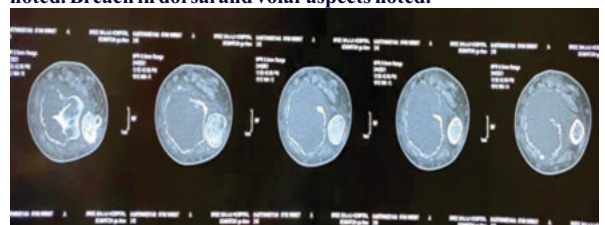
CT - Scan (AXIAL-VIEW) Showing Breach Of Cortex
